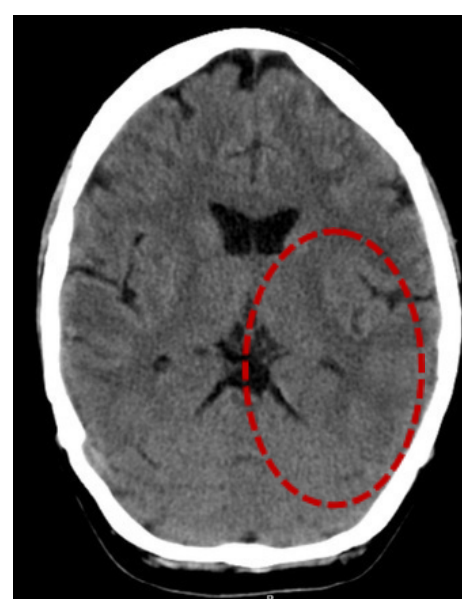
CT scan showing loss of grey-white matter differentiation in post central gyrus
